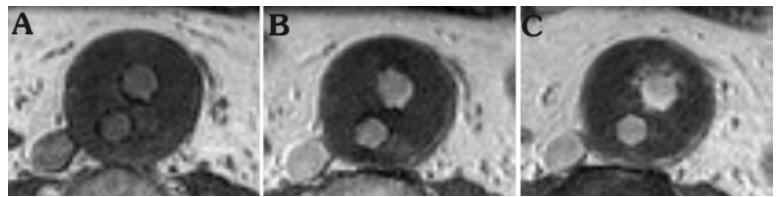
Transverse T1-weighted spin echo images a) pre-contrast b) post-contrast 3 minutes after injection c) late phase 70 minutes after injection. c) shows an endoleak which seems to originate from a porous graft.
